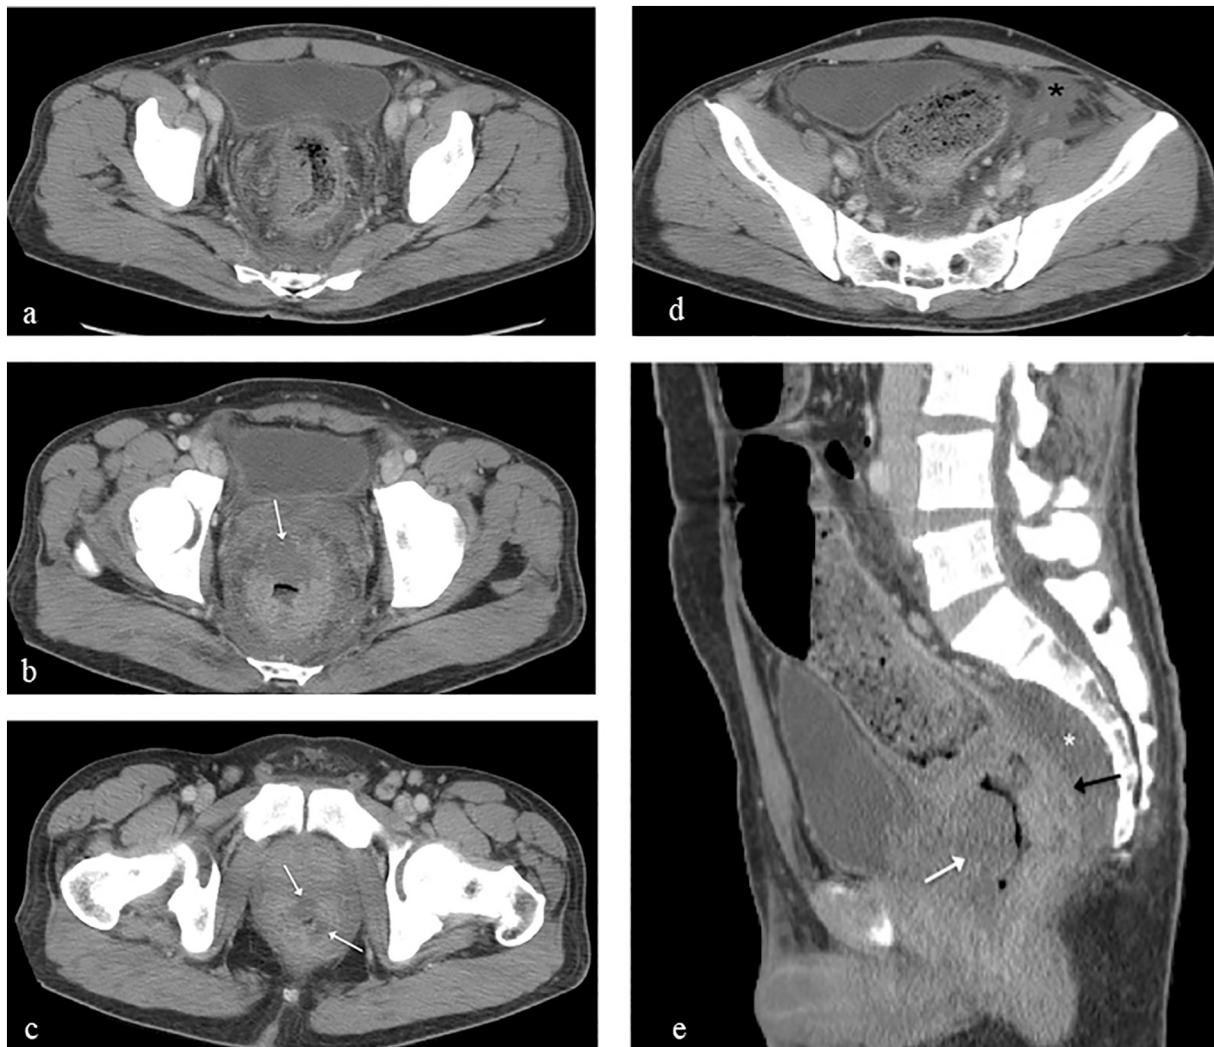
Axial images from contrast-enhanced CT scan of the abdomen and pelvis reveal (a) diffuse circumferential rectal mural thickening, hazy infiltrated perirectal fat, and presacral edema with discrete geographic non-enhancing hypoattenuated zones (white arrows) in the rectal (b) and anal wall (c) due to large ulcerations and (d) pelvic ascites (black asterisk). Several bilateral inguinal lymph nodes measuring up to 1 cm are seen on (c). Sagittal image (e) reveals the thickened enhancing posterior rectal wall (black arrow) contrasting a large anterior wall hypoattenuated ulcer (white arrow). Note prominent presacral edema (white asterisk). A small right pleural effusion is not shown.
